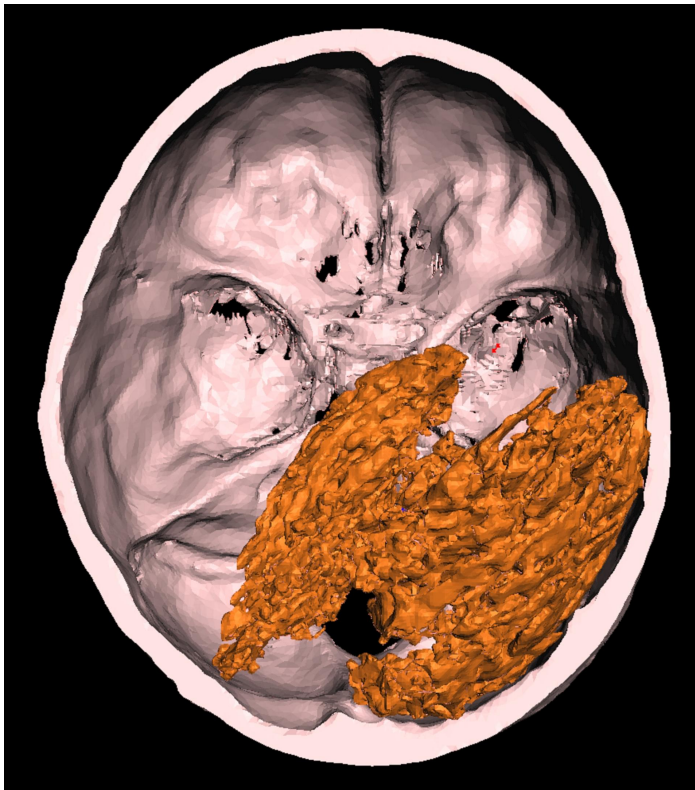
3D CT of section of skull base. The bi-lobed brain remnant (*in orange colour*) can be seen in right side of posterior cranial cavity.
